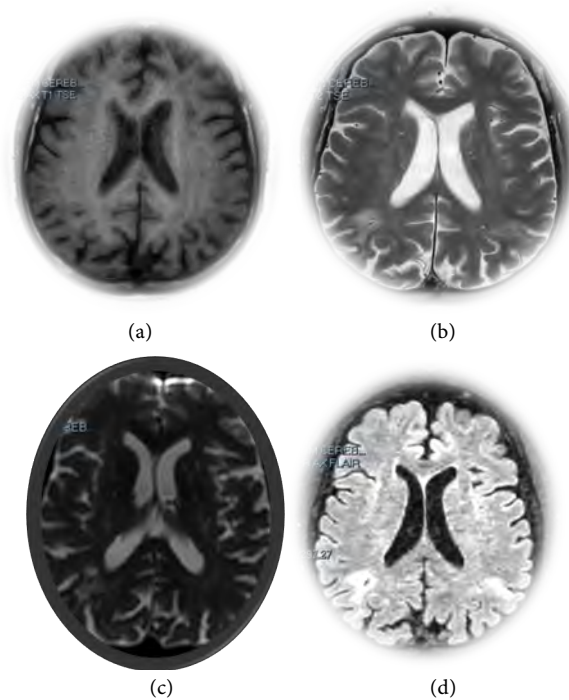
Brain MRI after 6 courses of chemotherapy. Significant regression of brain damage. (a) Axial T1 sequence; (b) Axial T2 sequence; (c) Diffusion sequence; (d) Axial flair.
